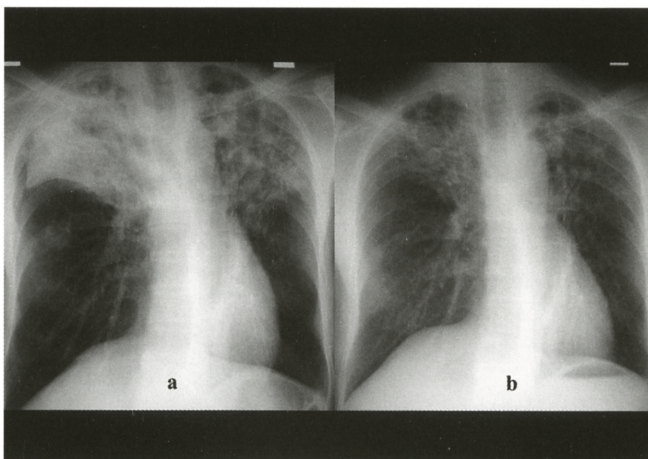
Chest radiographs (a, b) and plain chest CTs (c, d). On admission, lung opacities with multiple cavity formations of bilateral upper lung fields were observed (a, c). They improved after anti-tuberculous therapy for about 5 months (b, d).
